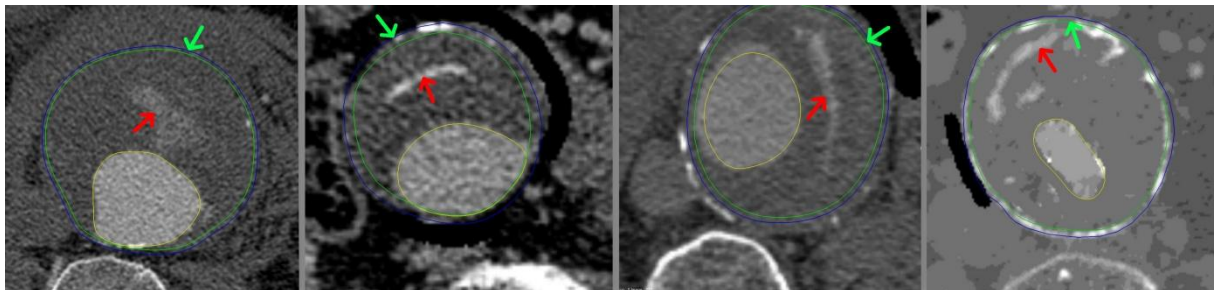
Reconstructed AAAs from CT-A images. The fissured ILT is indicated by red arrows. Sites, at which the highest stress increase was observed when considering ILT failure in the FE model, are marked by green arrows.
